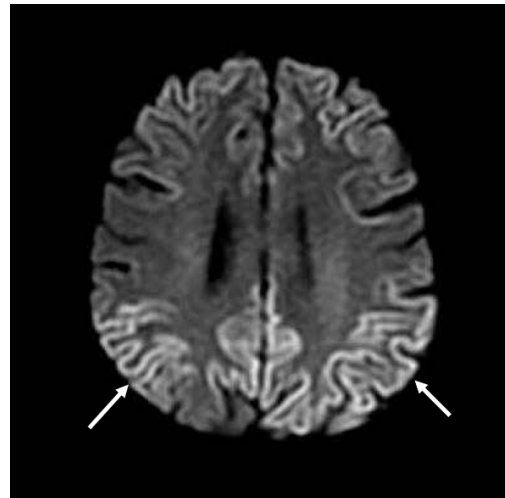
MRI Brain diffusion weighted imaging showed diffuse asymmetric cortical restricted diffusion involving bilateral cerebral cortices (left more than right) consistent with cortical ribboning (white arrows)
